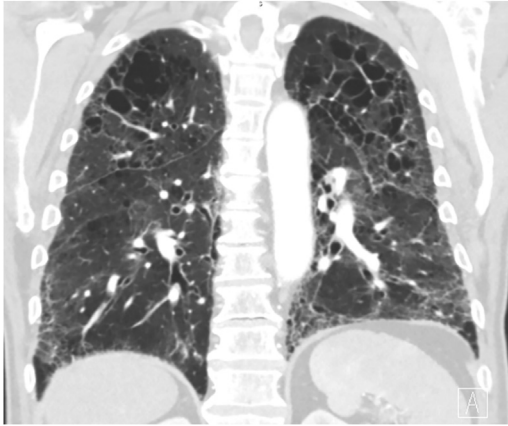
CPFE. Coronal CT image showing emphysematous changes predominantly in the upper lungs with a bibasilar and peripheral distribution of fibrotic changes.
